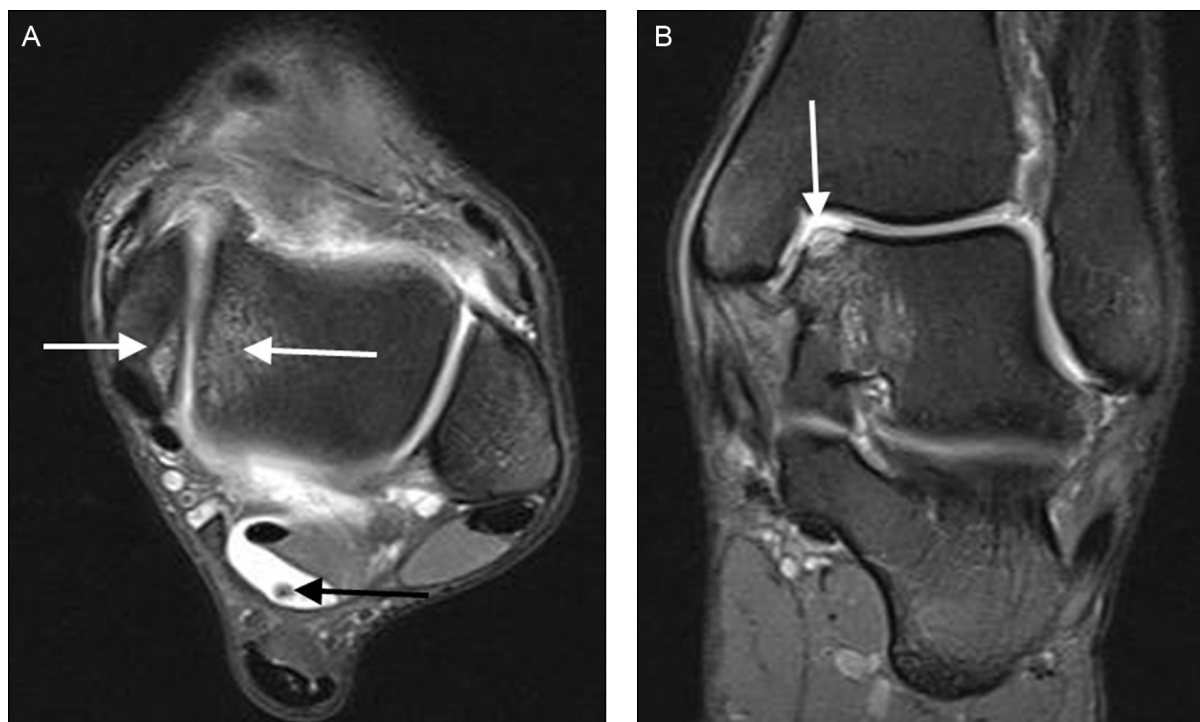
A 29-year-old female gymnast with posteromedial impingement syndrome. (A) Axial proton density-weighted fat-suppressed MRI shows bone marrow oedema at the medial talar dome and malleolus medialis (white arrow). Note a small loose body posteriorly (black arrow) within a small fluid collection posterior to the flexor hallucis longus tendon. (B) Coronal proton density-weighted fat-suppressed MRI shows an osteochondral lesion of the talus at the medial talar shoulder with full thickness cartilage loss (white arrow).
